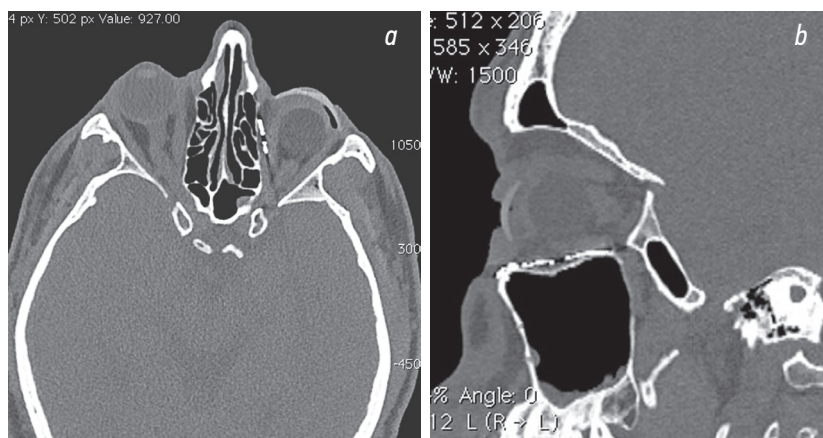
Multispiral computed tomography: *a* — axial view; *b* — sagittal view. Titanium mesh over the defect zones. Prosthesis is congruent to the stump shape
